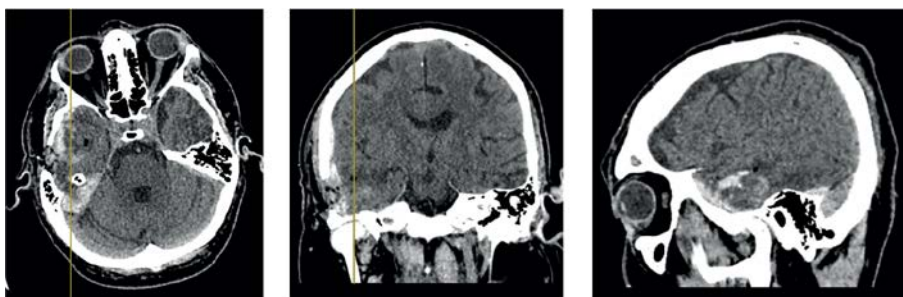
Brain CT of patient H., 40 years old, 2 hours after endoscopic removal of the ICH of the right temporal lobe
